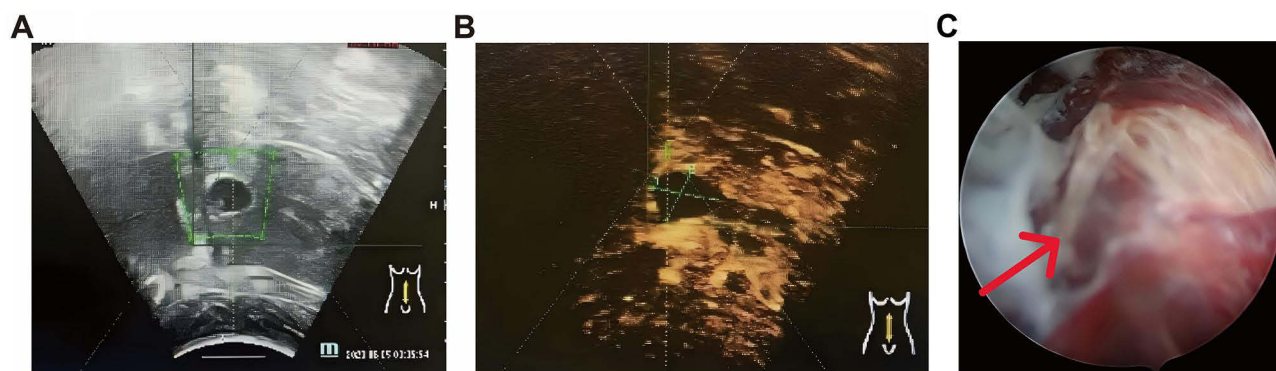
Intraoperative image and assessment of FUAS combined with hysteroscopic-guided suction curettage for CSP. (A) A sagittal ultrasound scan mode was selected to monitor the gestational sac (GS, As indicated by the green area marked). (B) Real-time contrast-enhanced ultrasound showed a lack of blood supply (As indicated by the green area marked) at the implantation site of the gestational sac. (C) Hysteroscopy assessed the uterine cavity, including the GS's position, shape, extent, and surface vascularity (As indicated by the red arrow).
